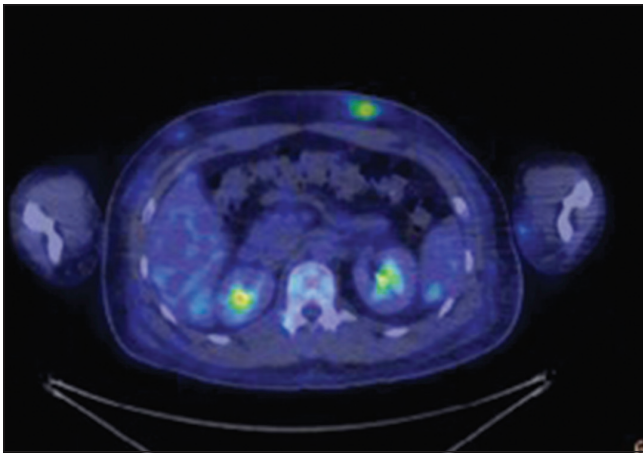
Positron emission tomography computed tomography shows multiple fluorodeoxyglucose-avid cutaneous lesions (green) with surrounding patchy foci of subcutaneous fat stranding (blue-grey) in anterior abdominal wall and upper left arm, compatible with areas of lymphomatous infiltrates.
